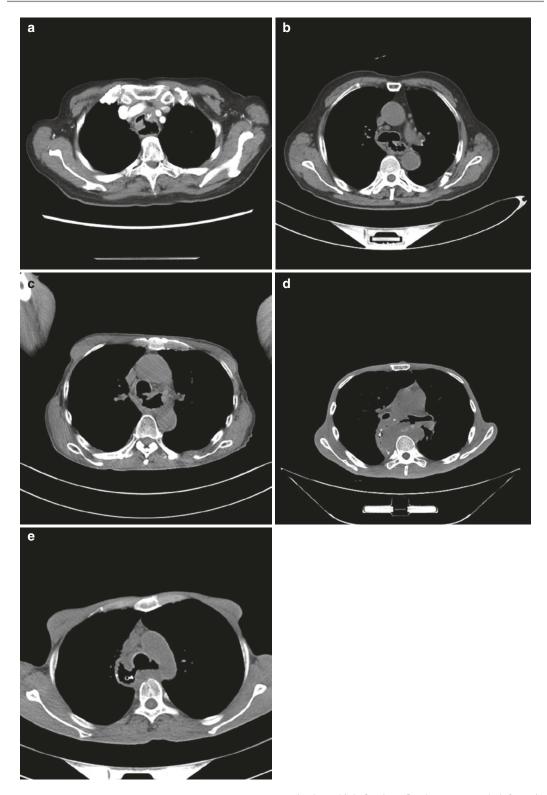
Several kinds of thoracostomach–airway fistula, CT image. (a) Thoracostomach–tracheal fistula; (b) thoracostomach–carina fistula; (c) thoracostomach–right
